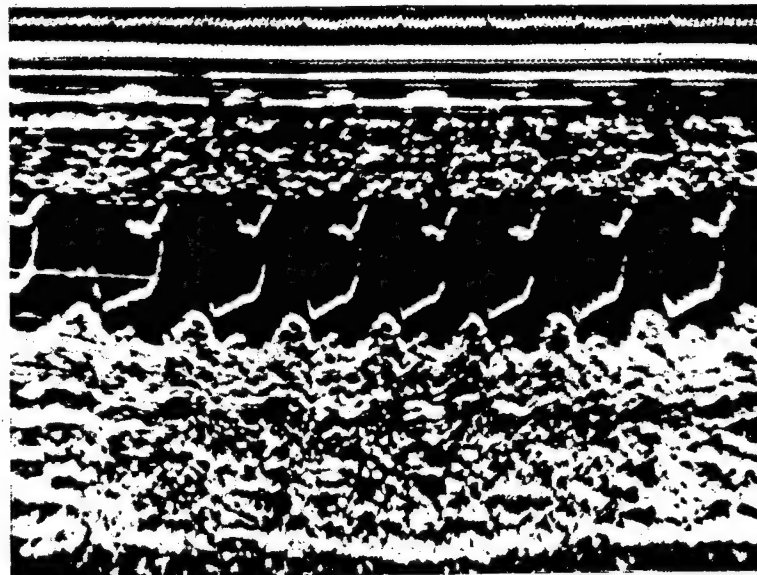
Incorrectly recorded echogram of left ventricle using Uzkar-3 echocardiograph
